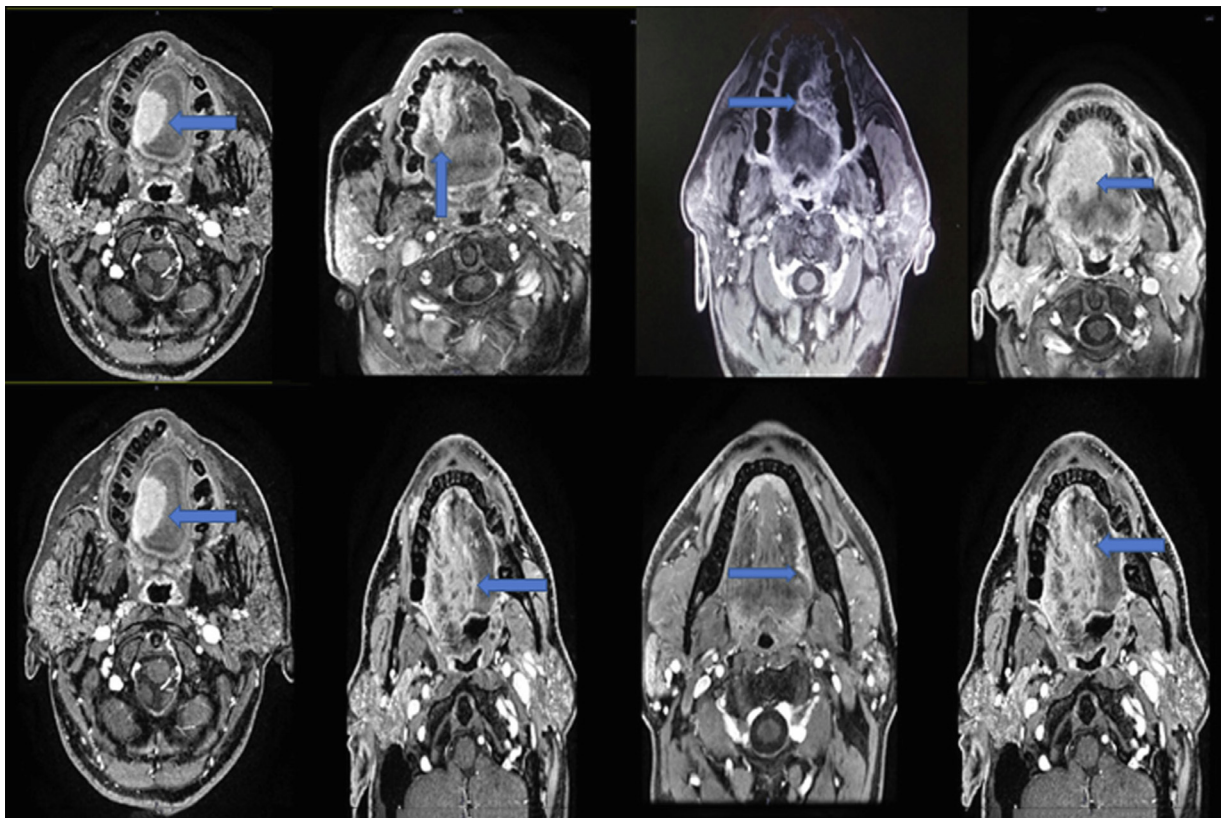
Different magnetic resonance imaging (MRI) features in squamous cell carcinoma of the tongue. *Top row*, Advancing tumor margin. *Top left to right*, Tongue tumor, with arrow showing smooth margin, single-finger advancement, multiple-finger advancement, and ill-defined margin. *Bottom row*, Patterns of tumor enhancement and enhancement beyond the tumor margin. *Bottom left to right*, Homogeneous enhancement, heterogeneous enhancement, enhancement absent beyond the tumor margin, enhancement present beyond the tumor margin.
